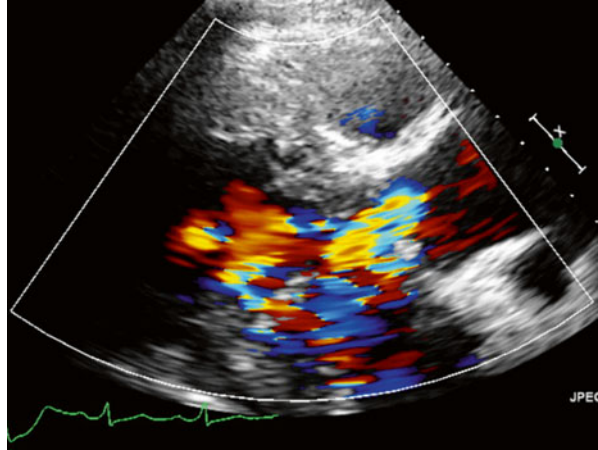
Echocardiogram of the described patient case demonstrating retrograde blood flow across the valve in AR
